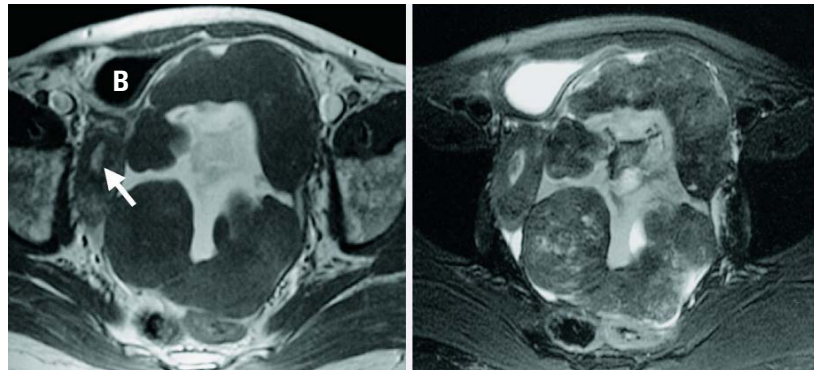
MRI: T1-weighted image (left) and T2-weighted (right) of a borderline clear cell cystadenofibroma of the left ovary. The huge multicystic tumour fills the pelvis almost completely. The uterus with endometrial hyperplasia (arrow) is pushed to the right iliac bone, and the urinary bladder (B) is compressed.
